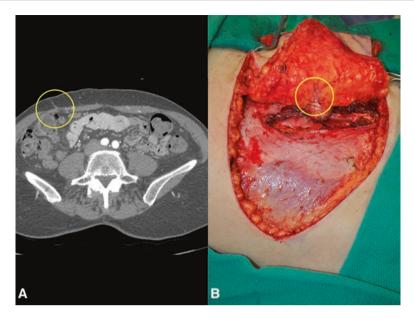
(a) Computed tomography angiogram (CTA) image demonstrating right hemi-abdomen perforating vessels from the deep inferior epigastric pedicle. (b) Intraoperatively identified perforator correlating to preoperative perforator mapping with CTA
